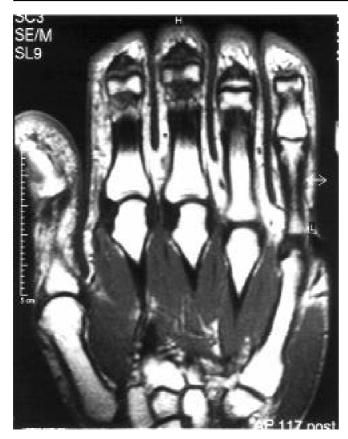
Coronal view of a normal hand using a T1-weighted SE sequence.
